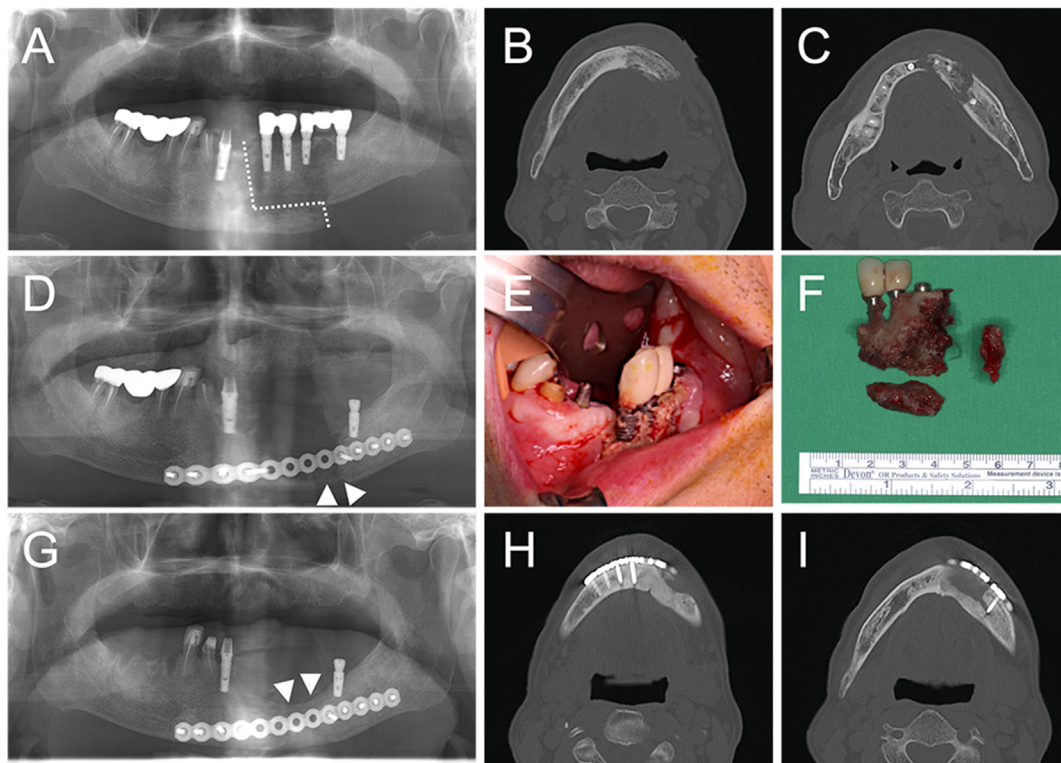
Perioperative imaging data of Case 3. (A) Preoperative panoramic view (dotted line, fracture line). (B, C) Preoperative computed tomography images. (D) Immediate postoperative panoramic view showing realigned fracture segments with direct bony contact (arrowhead) to restore mandibular continuity. (E) Intraoperative clinical photograph. (F) Removed sequestrum. (G) Panoramic view at two years postoperatively showing complete bone healing (arrowhead), restored continuity, and increased bone volume. (H, I) Computed tomography images at 7 months postoperatively.
